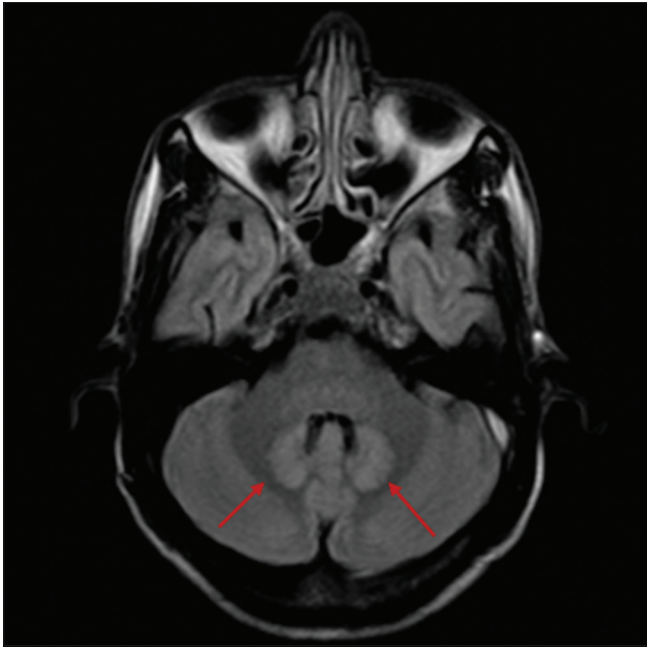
Axial FLAIR image shows bilateral symmetrical hyperintense signal in dentate nuclei of cerebellum
